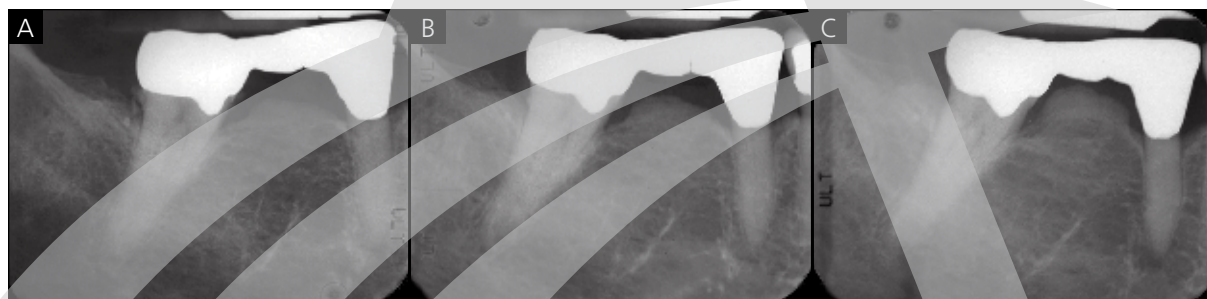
(Case No. 1) Periapical radiographic images of the fixed partial denture (FPD). A. Eleven years prior to treatment. B. Six years prior to treatment. C. Fourteen months prior to treatment. Note the progressive increase in lesion dimensions, the obliteration of the space under the pontic, and the increasing proportion of the radiopaque, cortical bone-like, coronal aspect of the lesion.
